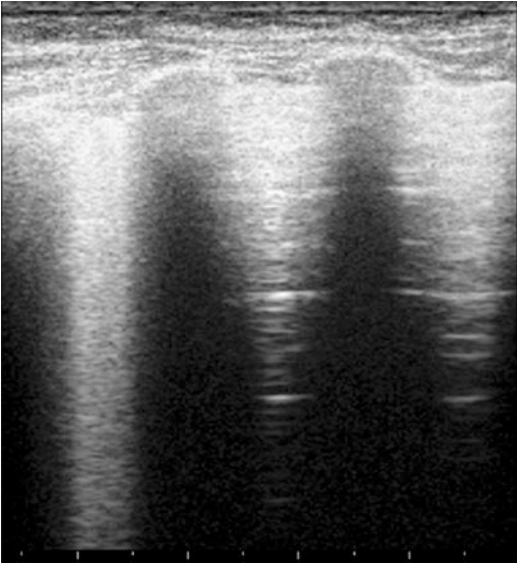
Car crush: 3 days later, lung ultrasound confirmed alternance of B-lines and A-lines, named spared areas; signs suggestive of ARDS; the ultrasound imaging is similar to TC
